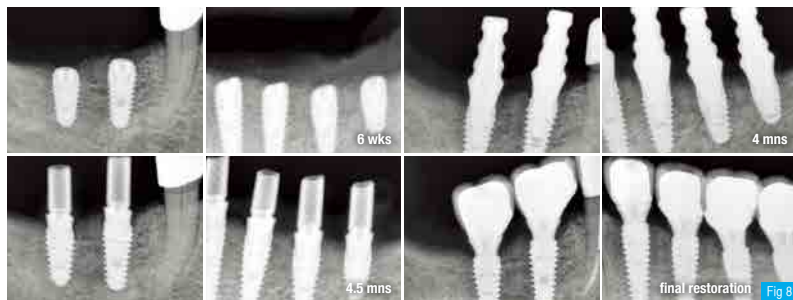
Intraoral radiographs taken at the following procedures. The crestal bone was well maintained with excellent bone regeneration with the ridge split technique.
